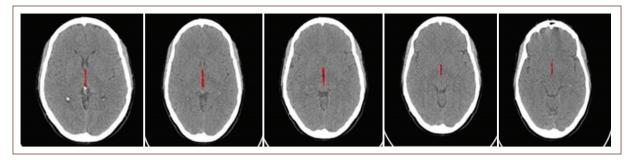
Segmentation of the third ventricle in computed tomography images. Source: Collection of images in DICOM formats the Department of Imaging of the Saturnino Lora Hospital.
